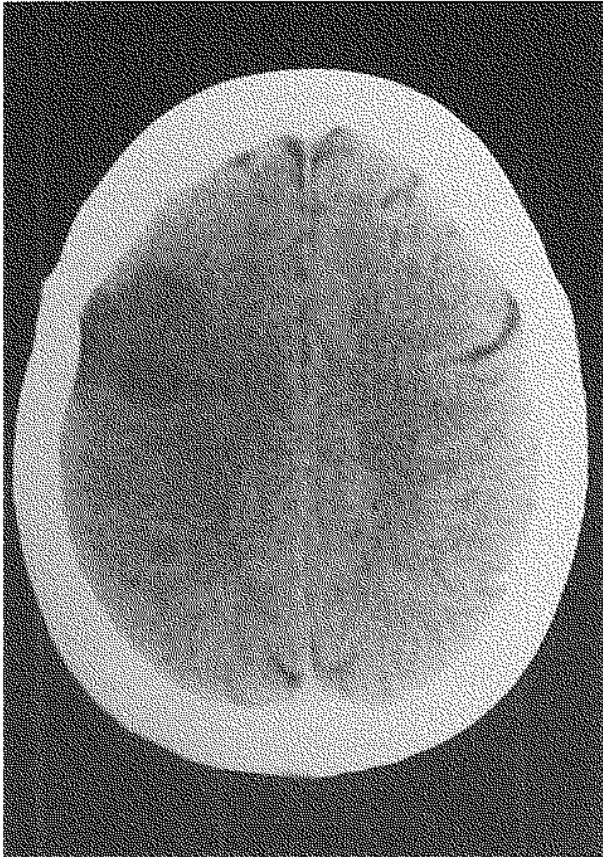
CT scan showing a hypodense left frontoparietal lesion, suggesting an embolic occlusion in the middle cerebral artery territory.
